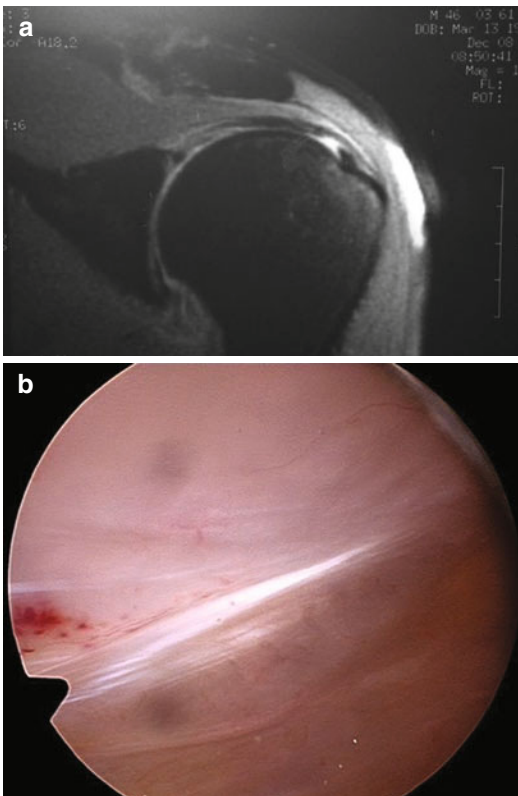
High-grade partial-thickness tear in a 17-year-old gymnast. (a) MRI read as “high-grade partial or complete rotator cuff tear.” (b) Bursal view of shoulder. Note that the bursa is pristine, consistent with the absence of impingement in these cases
